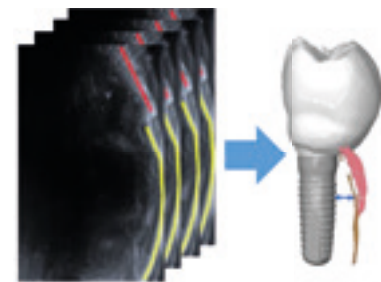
Intraoral Ultrasound for Implant Monitoring.
